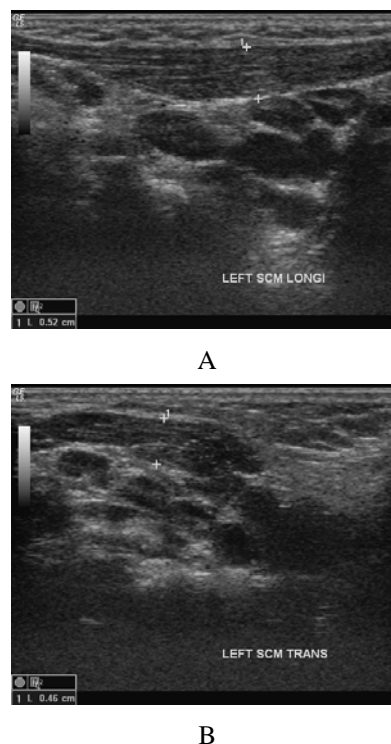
(A)Longitudinal view (B)Transverse view of left sternocleidomastoid muscle. Ultrasonographic images reveal no abnormal echogenicity nor increased thickness in the left sternocleidomastoid muscle (SCM).
